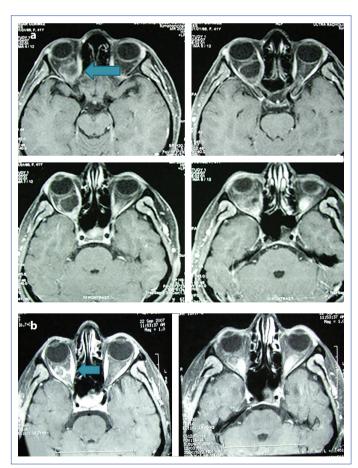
Axial T2-weighted contrast MR imaging shows a mass compatible with cavernous hemangioma compressing the left optic nerve from the superomedial aspect (a), and T2 -weighted axial contrast MR image obtained (b) after the left frontal craniotomy revealed complete removal of the mass.
